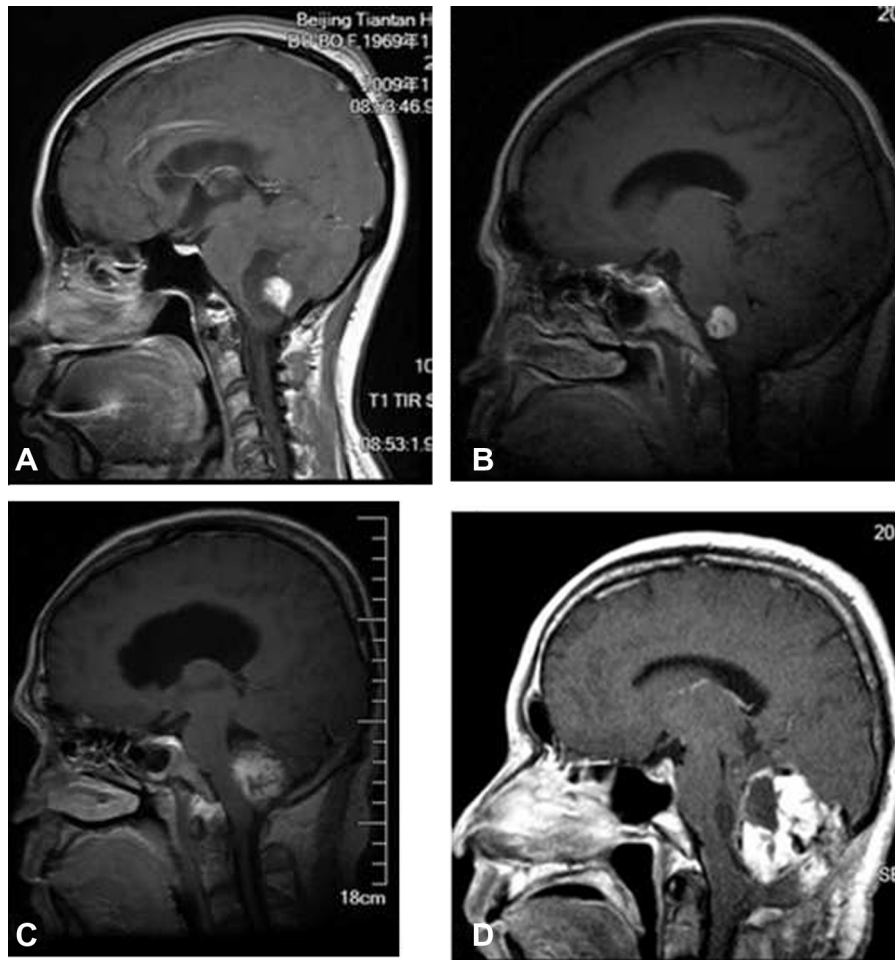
Sagittal T1-weighted MRI with gadolinium contrast showing (A) a predominantly cystic tumor (Type A; tumor nodule 0.1–1.5 cm), (B) a small solid tumor (Type B; <3 cm), (C) a large solid tumor (Type C; 3.1–5 cm), and (D) a giant solid tumor (Type D; >5 cm). (This figure is available in colour at www.sciencedirect.com.)
